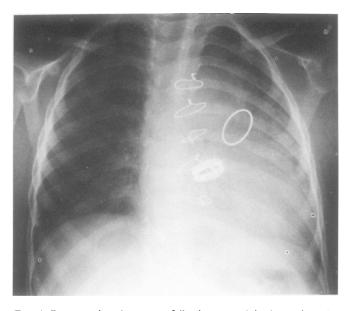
Postoperative chest x-ray following a conduit change in a 4-year-old child with massive truncal valve incompetence. Note the increased heart size remains, and the ring of the Bjork-Shiley aortic valve as well as the ring of the valve conduit are visualized.
